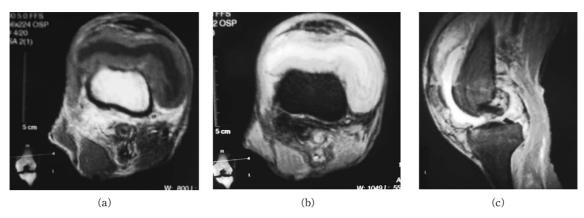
A MRI scan showing a wide low-intensity isointense area in the suprapatellar pouch. Abnormal lesions could not found in the bone marrow. (a) T1-weighted image (b) (c) T2-weighted image
